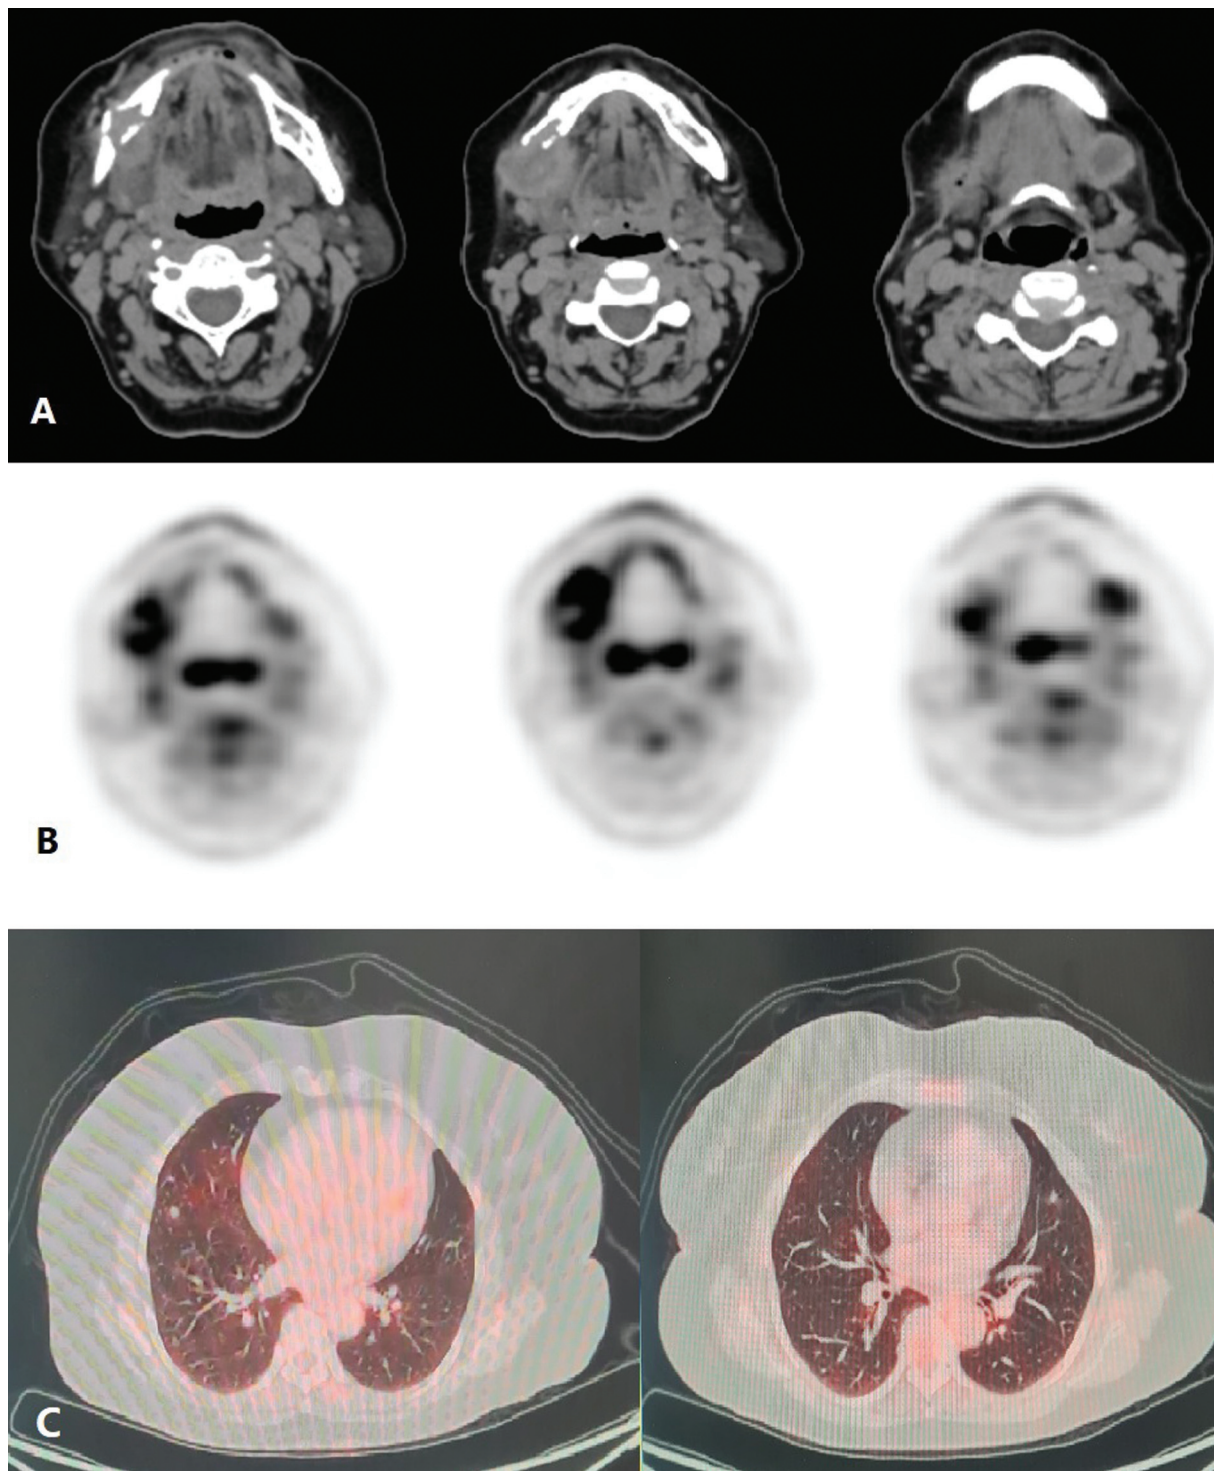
Contrast-enhanced computed tomography (CT) (A) and positron emission tomography (PET) images (B) showing soft tissue lesion seen in the right hemimandible causing cortical erosion and involving the submandibular gland inferiorly with an enhancing centrally necrotic left submandibular lymphadenopathy and (C) mild fluorodeoxyglucose (FDG) avid multiple parenchymal nodules were noted in bilateral lung fields suggestive of metastasis.
